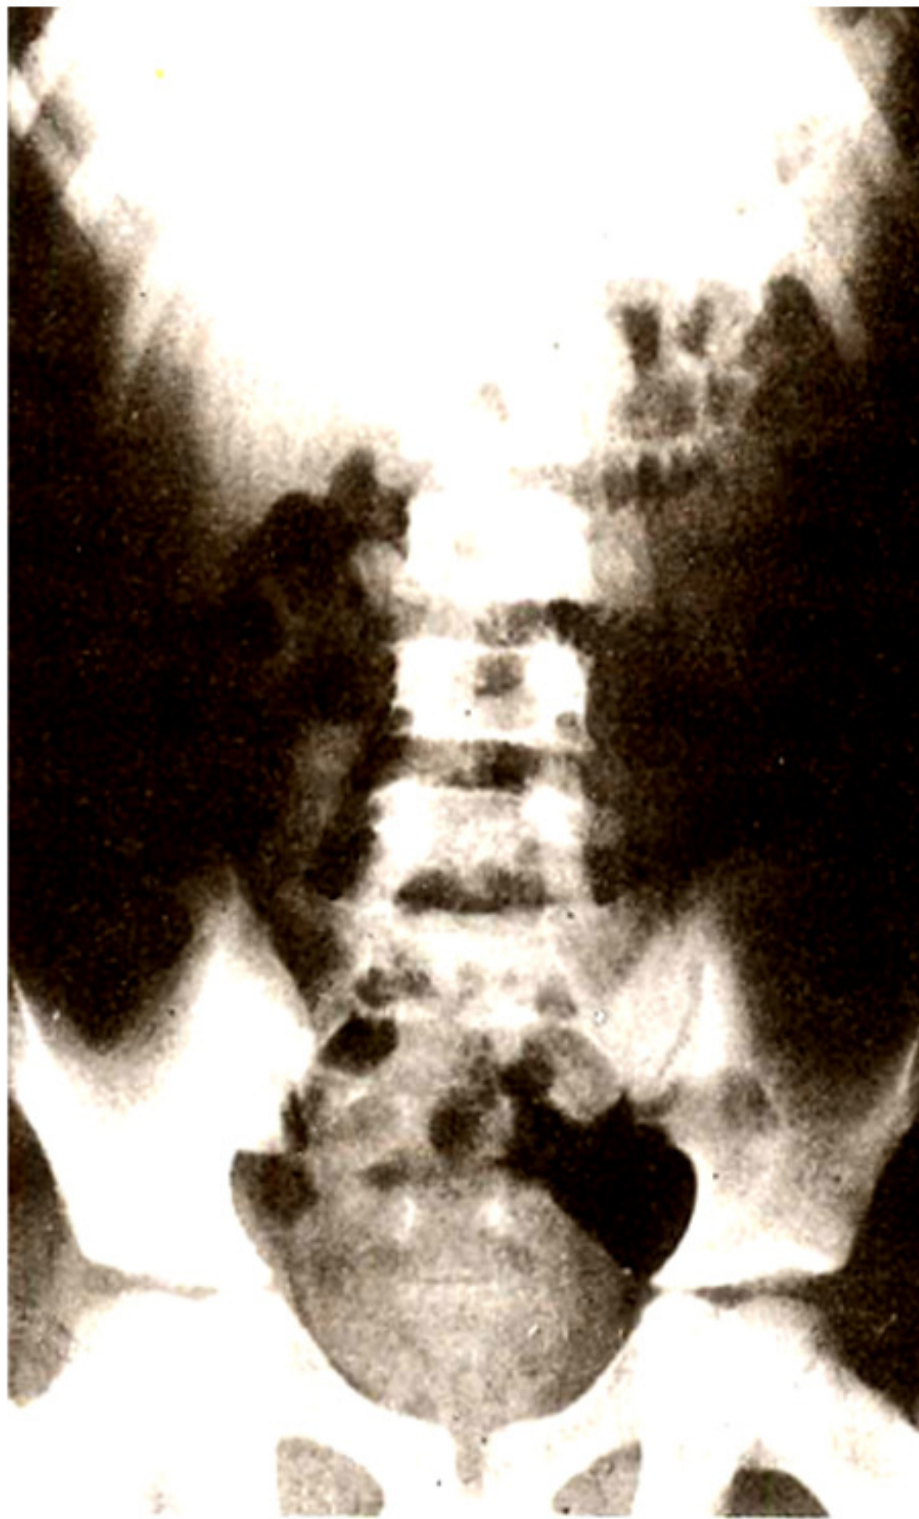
Follow-up X-ray after ureterorenoscopy showing clearance of stone.
